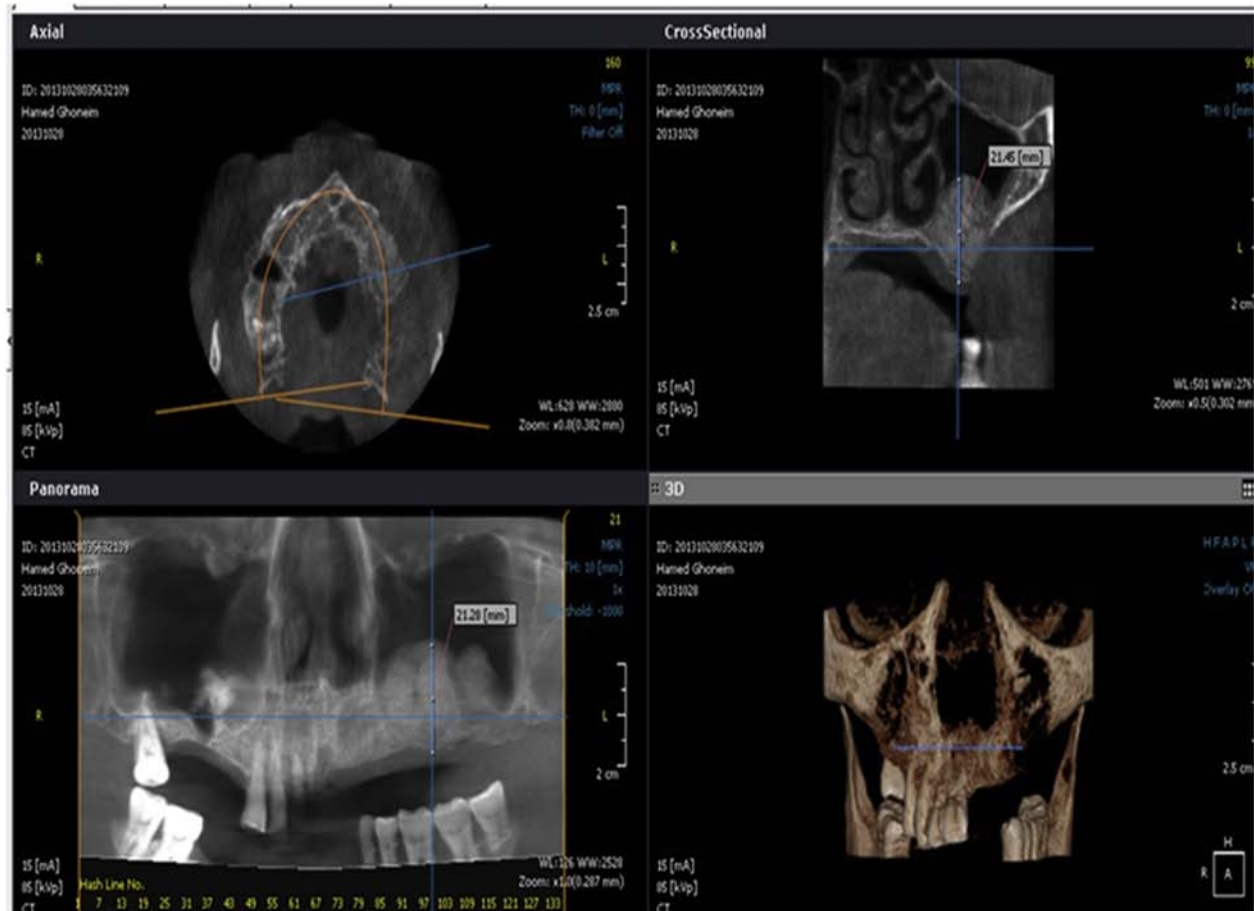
Immediate post grafting CBCT to assess the achieved sinus lift.
